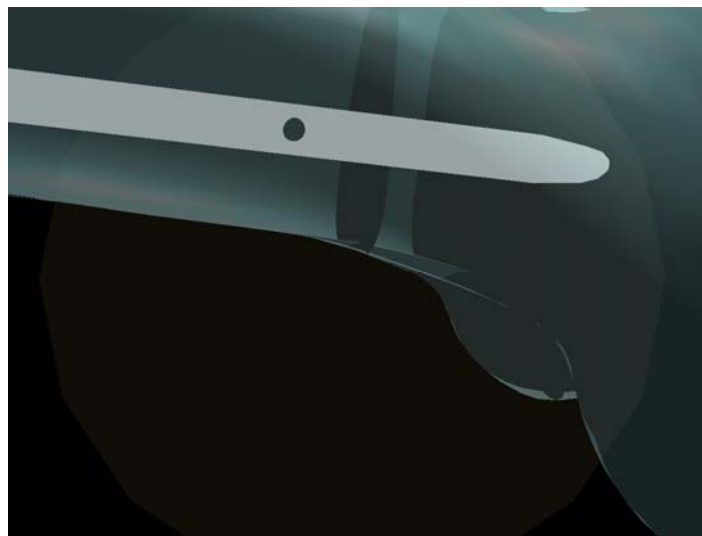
A virtual x-ray showing intramedullary femoral nail showing the distal locking screw-hole and distal femoral condyles.
